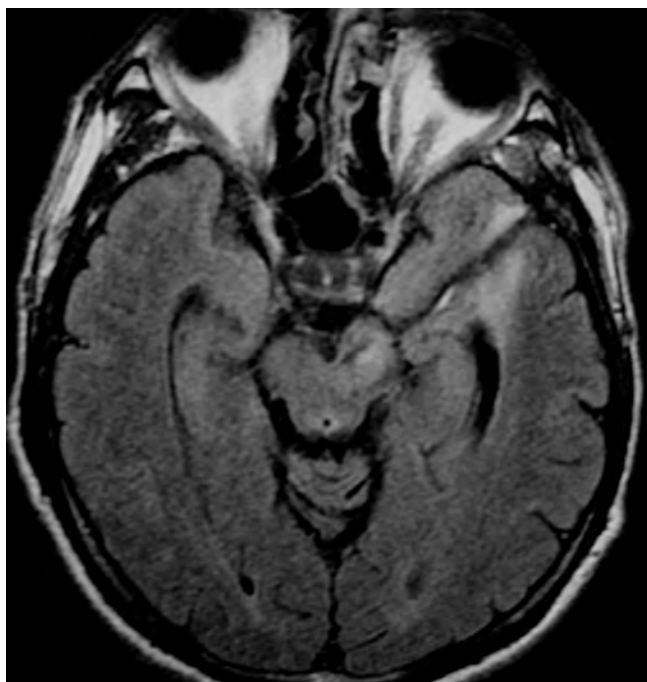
MRI Fluid-Attenuated Inversion Recovery secuencia showing well defined hypointense trajectory from malar region through temporal parenchyma into left cerebral peduncle with edema of the latter.
